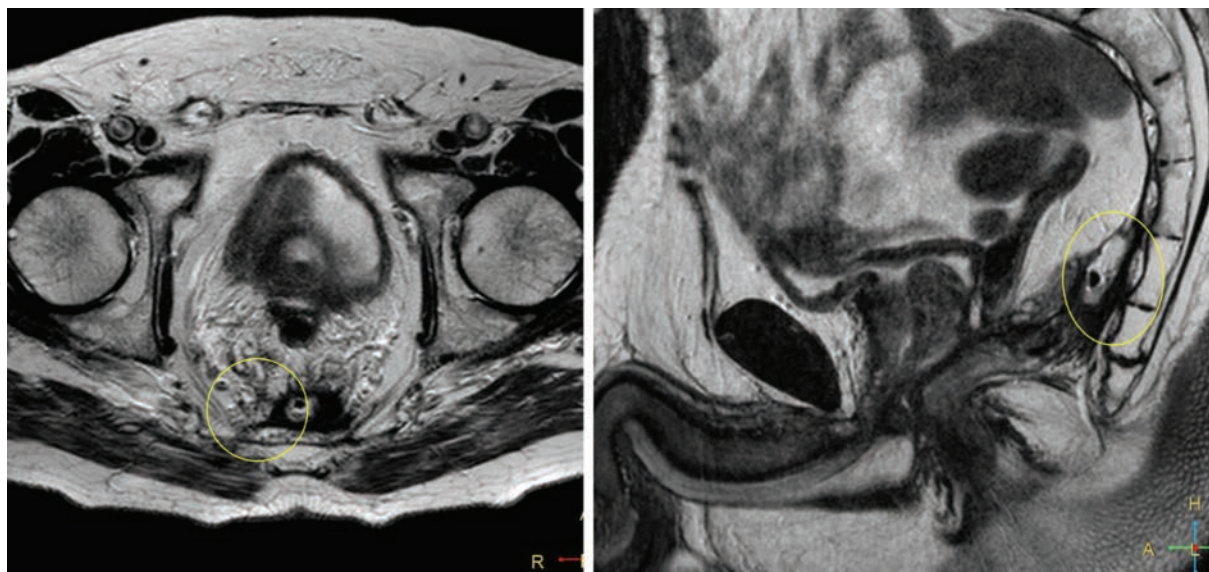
MRI of patient N.'s pelvis 6 months after anterior rectal resection (axial projection on the left, sagittal projection on the right): presacally, in the area of the anastomosis, a swelling with liquid contents, measuring 2.5×1.1 cm, surrounded by fibrous tissues, was revealed. The upper pole of the anastomotic sinus is at the level of the lower border of the S4 vertebra
